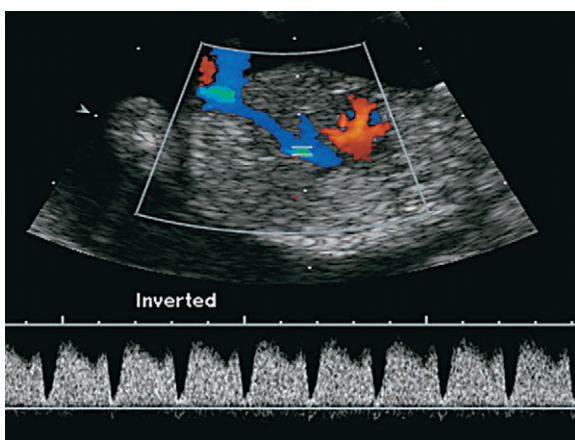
Ultrasound image of ductus venosus flow velocity waveform in a chromosomally normal 13-week fetus. The Doppler gate is placed in the ductus venosus between the umbilical venous sinus and the inferior vena cava. Note that there is biphasic pulsatile flow with constant forward flow. The troughs of flow during the atrial contraction also demonstrate forward flow.
